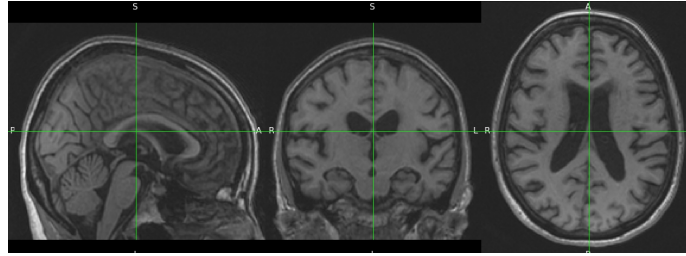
MRI after registration
